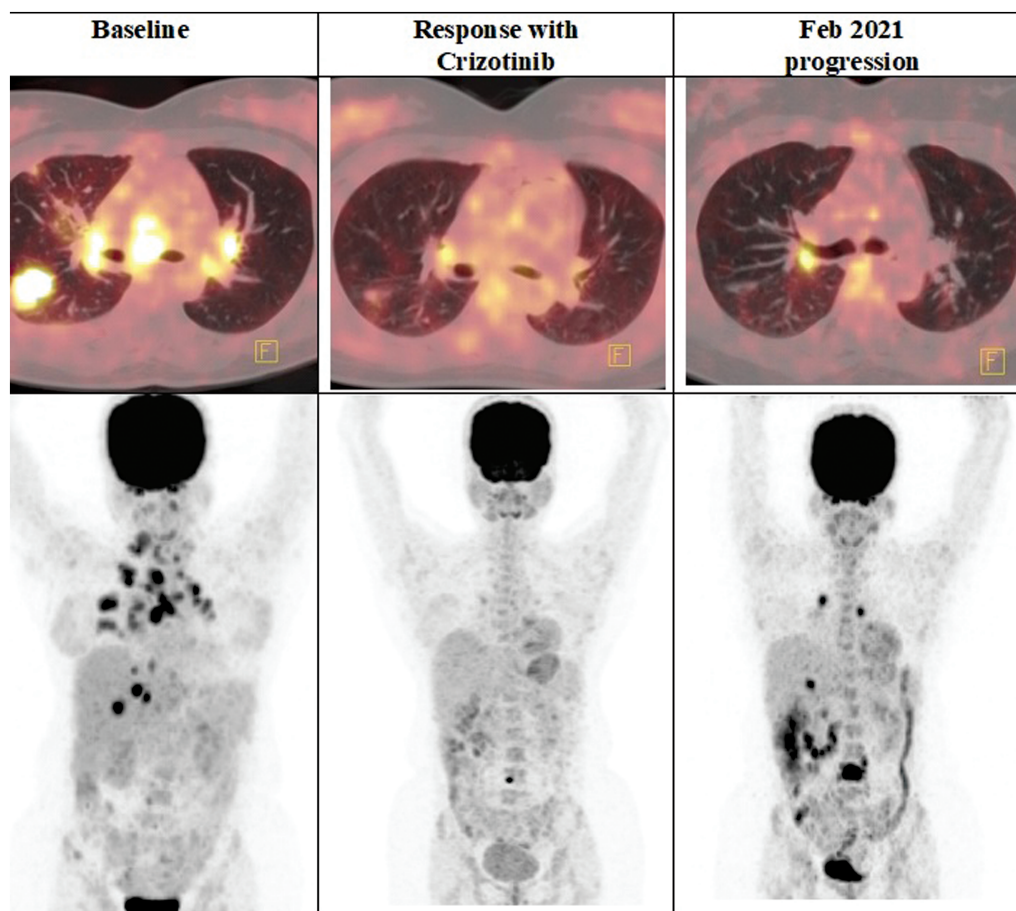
Positron emission tomography-computed tomography (PET-CT) findings indicating disease progression with the appearance of lung and liver lesions following 10 months of crizotinib administration.
